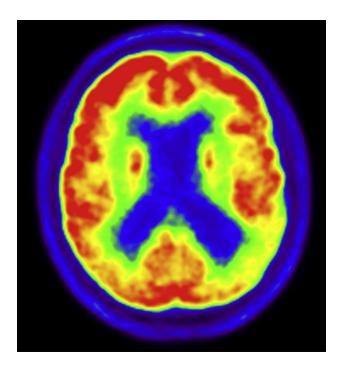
Fluorodeoxyglucose (FDG) positron emission tomography (PET); transaxial image at the level of the ventricular bodies showing reduced metabolism (yellow) in the posterior parietal and parietal-occipital junction region of both hemispheres compared with the normal metabolic activity (red) of the frontal lobes.
